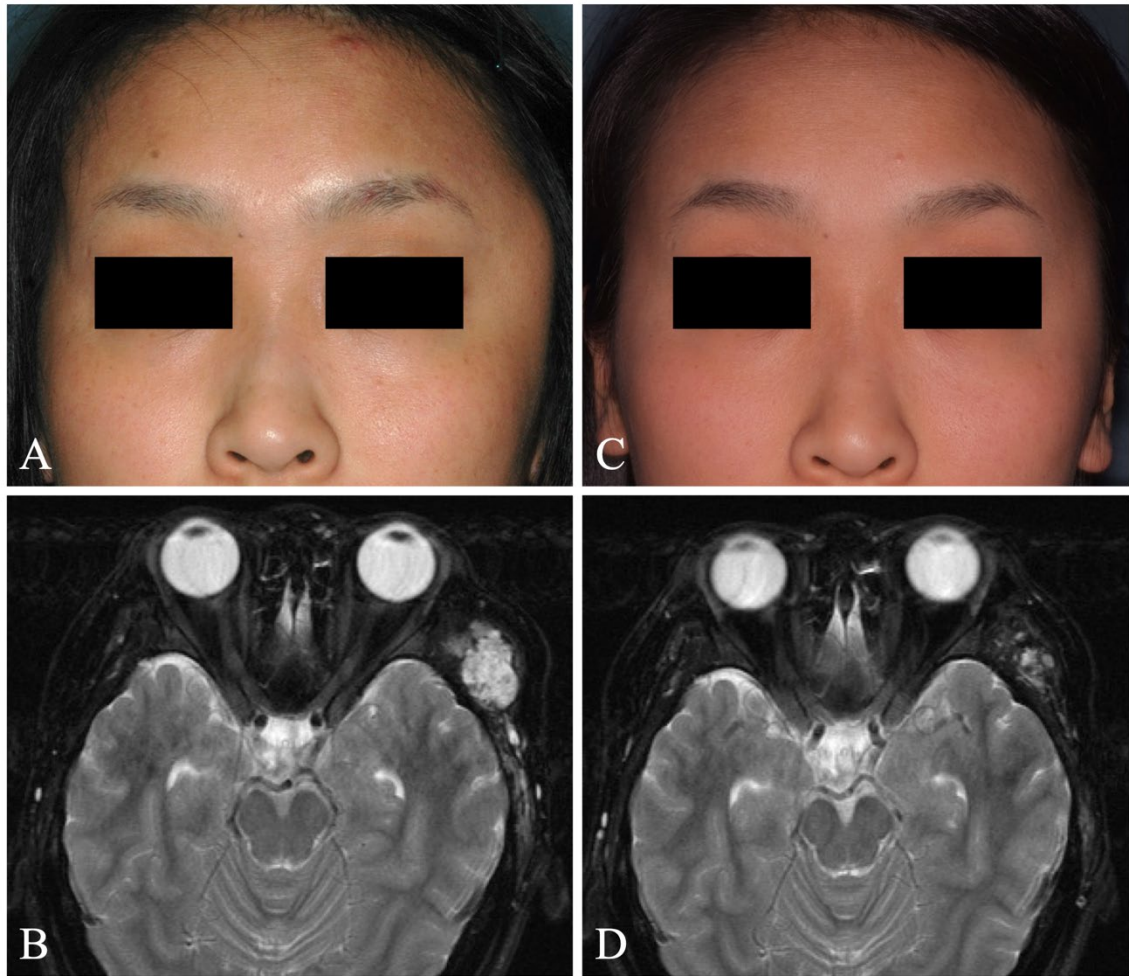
Patient 11 showed excellent effectiveness of treatment. (A) Clinical photograph and (B) fat-suppressed T2-weighted magnetic resonance image of a 23-year-old woman with venous malformation in the left temple. One session of sclerotherapy using ethanol was conducted at the age of 23 years. (C) Clinical photograph and (D) fat-suppressed T2-weighted magnetic resonance image obtained 8 months after the sclerotherapy. Complete relief of intralesional pain was obtained.
